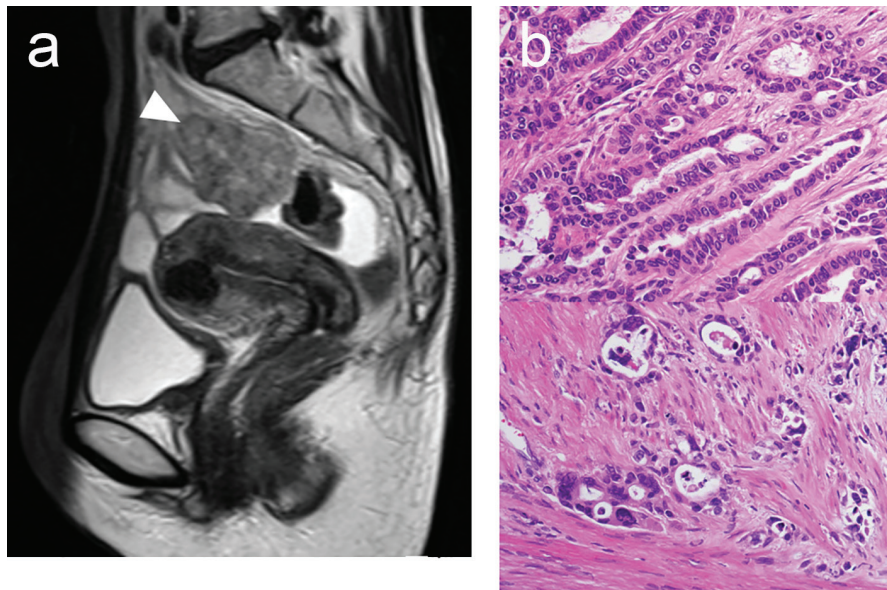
MRI in June 2012 revealed metastases in the right ovary and uterus (arrowhead) (a). Necropsy of the ovary metastasis demonstrated adenocarcinoma accompanied by trophoblastic differentiation (b).
